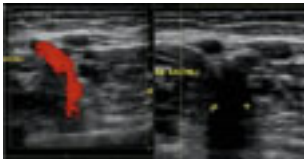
Perforator vein in the distal medial thigh: insufficient. Colour-doppler image (left) shows reflux (forward flow towards the superficial venous system) and B-mode image shows dilatation (diameter of 4 mm).
